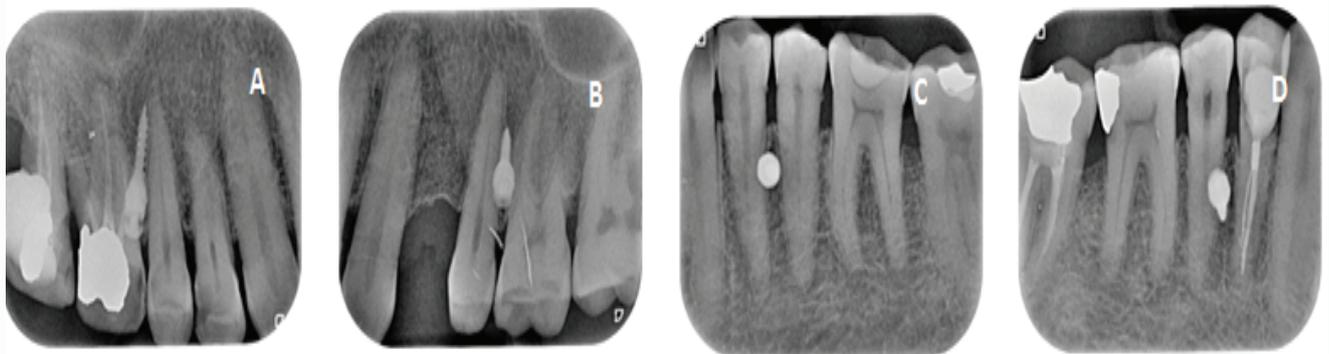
Intra-oral periapical radiographs of the mini-screws after insertion; A) Maxillary right side B) Maxillary left side C) Mandibular left side and D) Mandibular right side.
